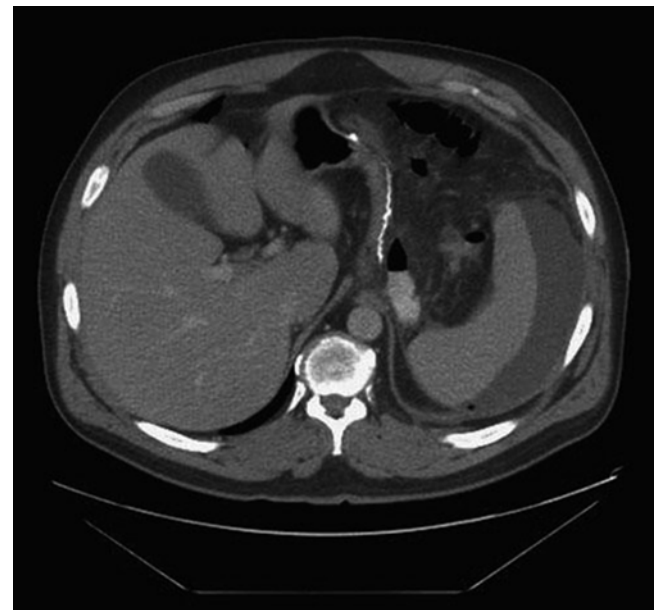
Abdominal CT scan showing the staple line of the sleeve gastrectomy with contrast extravasation proximally into an extraluminal collection immediately adjacent to the gastric sleeve staple line. Reproduced with permission from *OBES SURG 2010*;20:1289-1292. The Use of Endoscopic Stent in Management of Leaks After Sleeve Gastrectomy.
